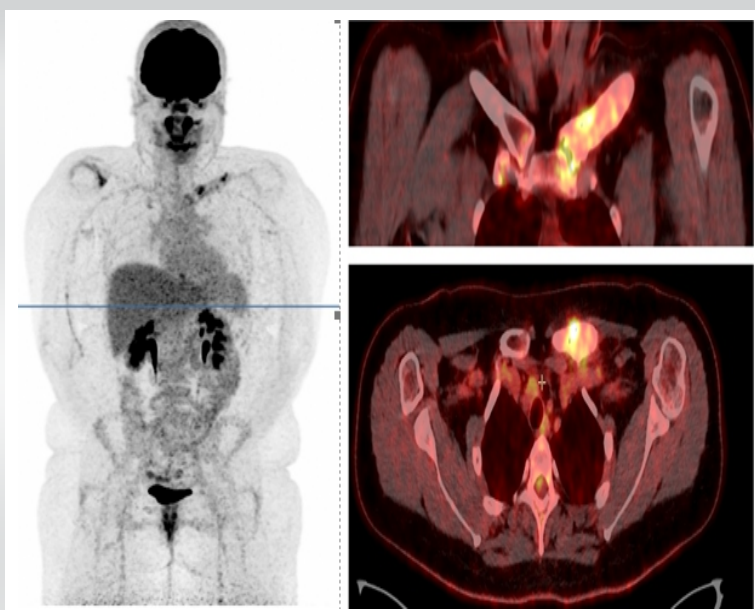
18F-Positron emission tomography computed tomography showing metabolic uptake uniquely at the left clavicle (SUVmax 3.1).
